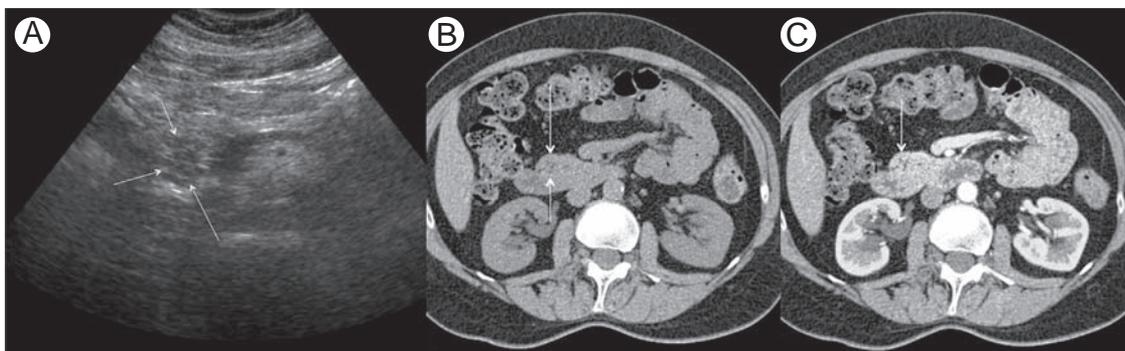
Focal fatty replacement in the head of the pancreas in a 55-year-old asymptomatic man. Ultrasound image (A) shows a 2.0-cm heterogeneous, mostly hypoechoic, solid nodule in the head of the pancreas (arrows). Subsequent axial unenhanced (B) and contrast-enhanced arterial phase (C) CT images demonstrate multiple tiny foci of fatty replacement in the head of the pancreas with surrounding normal parenchyma (arrows).
